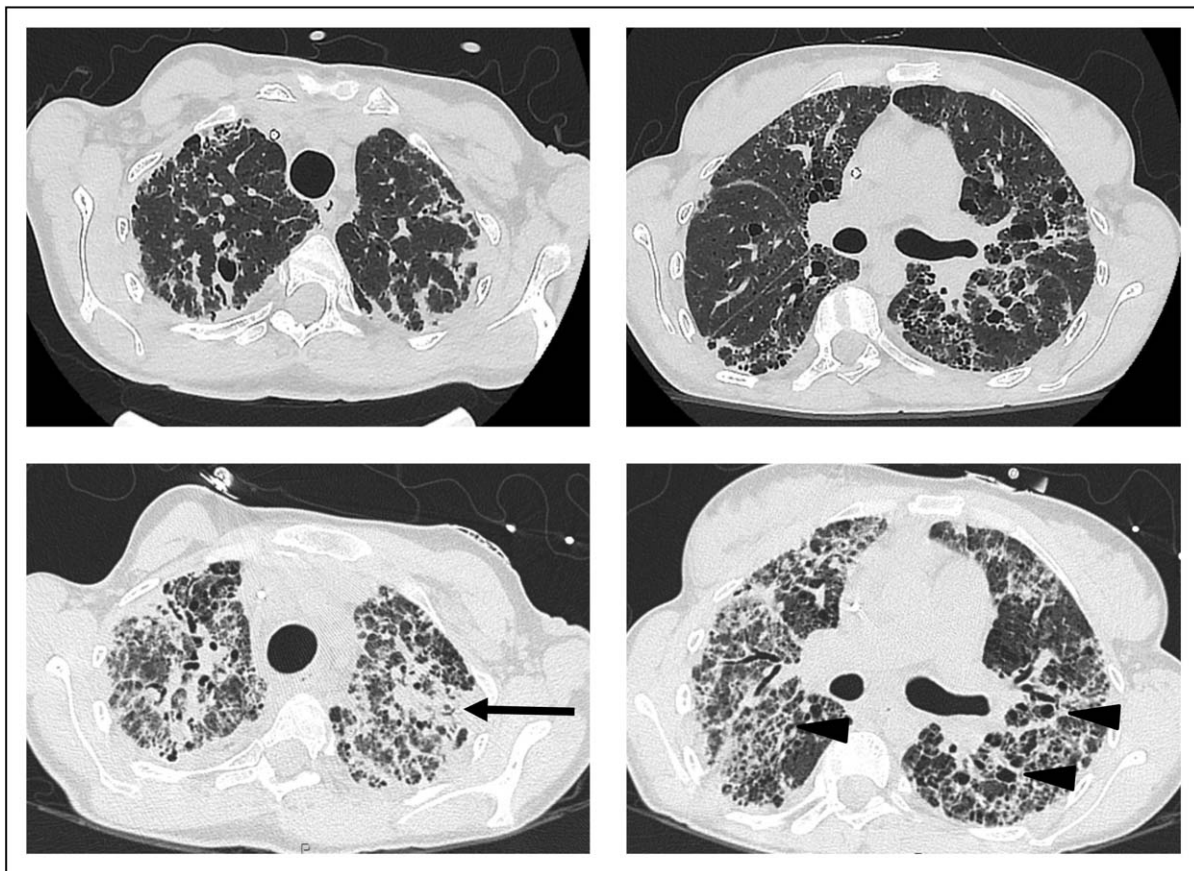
Acute exacerbation of interstitial lung disease in a 24-year-old Nigerian woman with COPA syndrome. Diffuse ground glass opacity and reticular changes mixed with areas of consolidation (arrow) are distributed predominantly in the mid-upper zones of the lung. These abnormalities, which are either peribronchovascular or diffuse in distribution, are superimposed on a background of cystic abnormalities (arrowheads). The two computed tomography scans (top left and right vs. bottom left and right) were performed 3 weeks apart.
